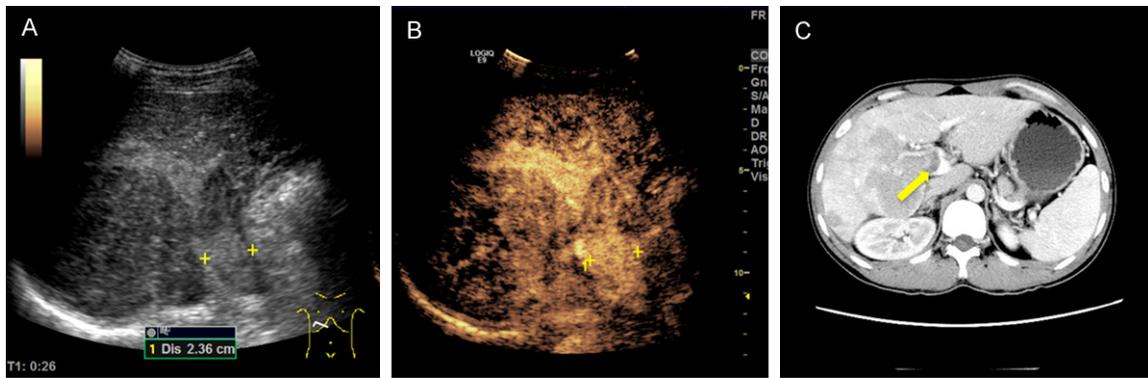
PVTT in portal vein trunk. A: Conventional ultrasound imaging. B: CEUS imaging. C: Enhanced CT imaging.
